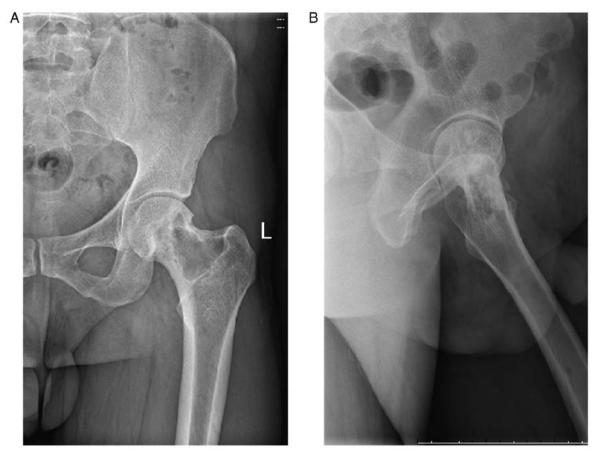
(A) Orthogonal and (B) lateral x-ray of the left hip joint. X-ray images indicate a benign bone disease with a high probability of aneurysmal bone cyst.
